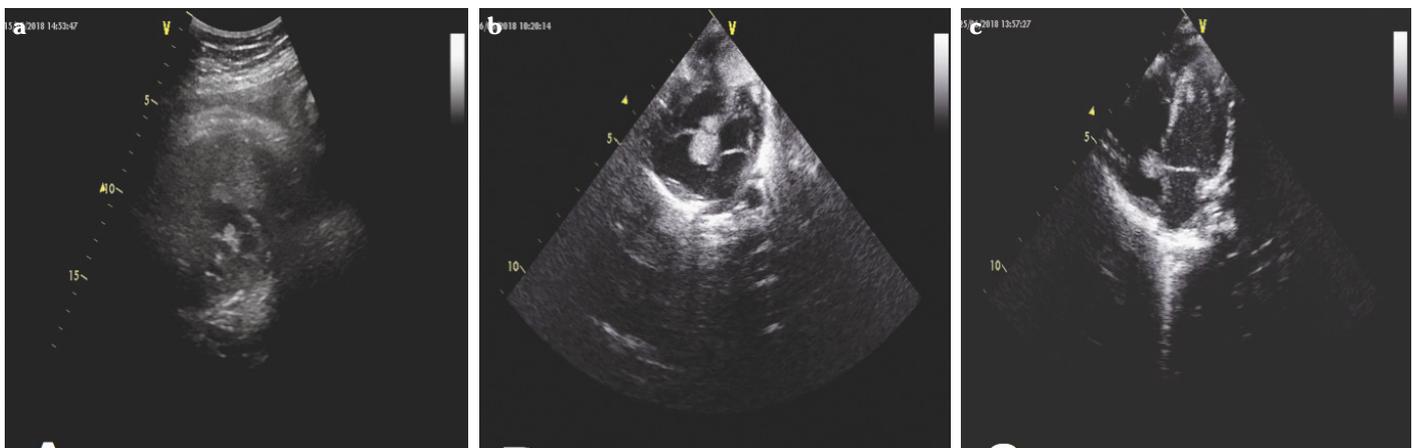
a–c. (a) Fetal echocardiography showing multiple cardiac rhabdomyomas. (b) Echocardiographic appearance of the patient at the time of diagnosis: a rhabdomyoma in the right atrium extended into right ventricle through the tricuspid annulus and different sizes of multiple rhabdomyomas localized in the left ventricular apex, right and left ventricle cavity in apical 4-chamber view. (c) Echocardiographic views of rhabdomyomas after 3-month follow up. Note the regression of rhabdomyomas
